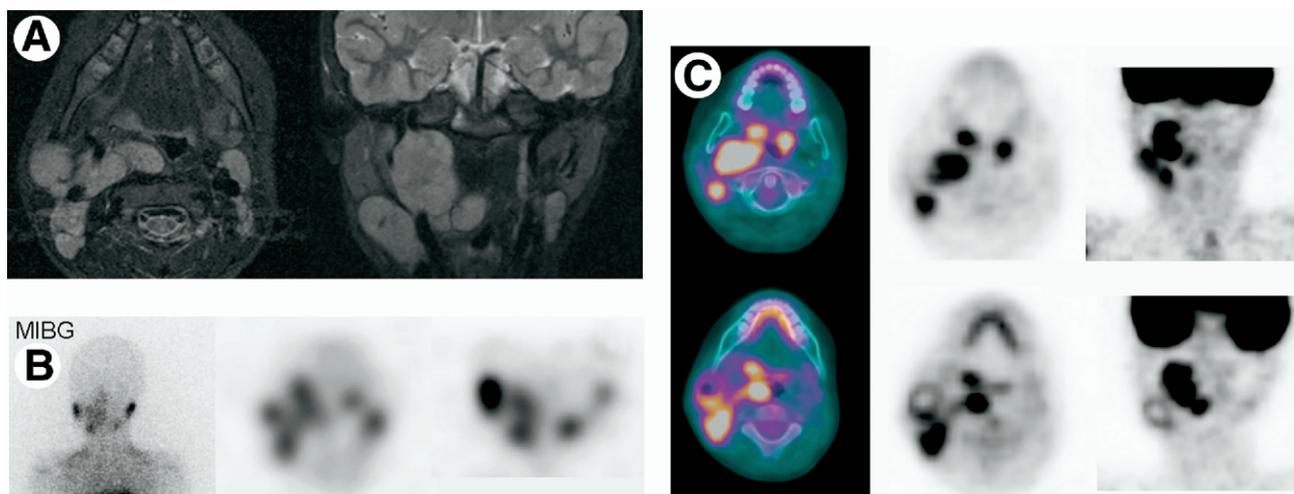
(A) MRI (left transaxial, right coronal) short-TI inversion-recovery image in a 4-year-old girl shows a large mass with abnormal lymph nodes in the right side of the neck with displacement of the right tonsil and possibly abnormal nodes in the left neck. (B) ^{123}I -MIBG anterior planar image (left) shows abnormal uptake in the mass. The SPECT images (center, transaxial; right, coronal) shows uptake within the mass; however, there is difficulty in differentiating the tumor mass from salivary glands and lymph nodes on the right and left side. (C) The coregistered PET/CT FDG study shows clear demarcation of the mass, lymph nodes and tonsils. The mass shows marked metabolic activity, and there is necrosis in one of the enlarged lymph nodes in the right neck. No abnormal nodes were detected on the left side. This allowed more accurate staging to stage 2 with no involvement on the left side of the neck.
